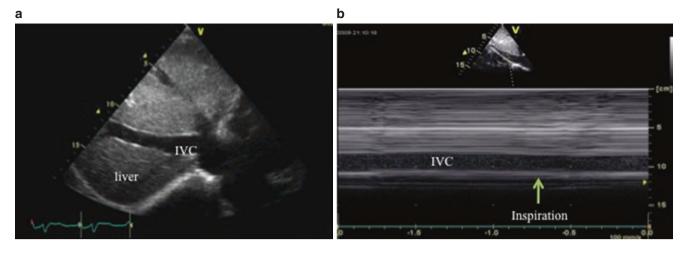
Demonstrates 2d-echocardiography subcostal long-axis view with a dilated IVC (\mathbf{a}) and M-mode echocardiography with no respiratory variation of the IVC size, suggesting high right heart filling pressure (\mathbf{b}). IVC inferior vena cava
